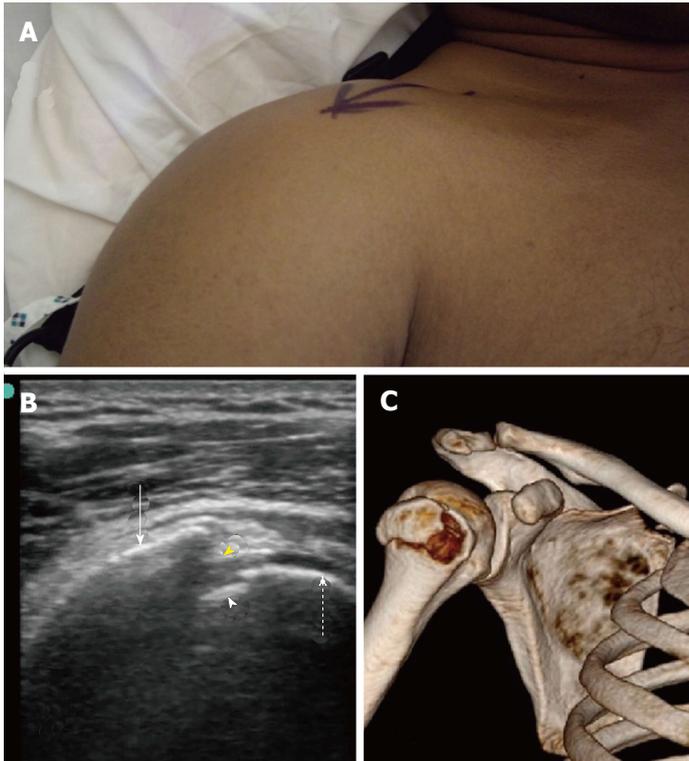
Point-of-care ultrasound of a 40-year-old front seat male passenger who was involved in a front impact collision with a tree. When presenting to the hospital, he had severe pain, swelling and limitation of the movement of the right shoulder (A). B mode point-of-care ultrasound of the right shoulder using a linear probe having a frequency of 10-12 MHz (B) shows that the humeral head (dashed arrow) and the greater humeral tuberosity (white arrow). There is a discontinuity of the bony line (yellow arrow head) indicating a fracture in the greater tuberosity. A small piece of fractured bone is also seen near the humeral head (white arrow head). Three-dimensional bony reconstruction of the right shoulder confirms the ultrasound findings (C). Ultrasound study was performed by Professor Fikri Abu-Zidan, Department of Surgery, Al-Ain Hospital, Al-Ain, UAE.
